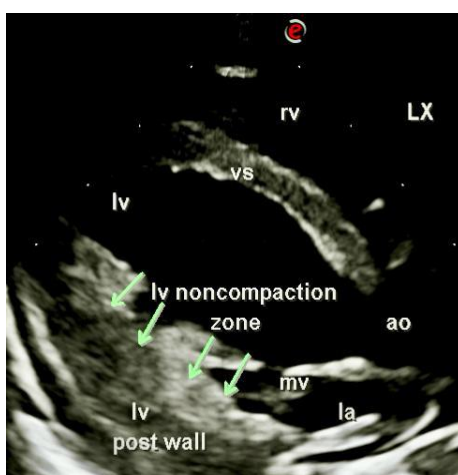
Transthoracic Echocardiography (TTE). In the LX view a salient LV non compacted zone of post wall is demonstrated. lv, left ventricle; la, left atrium; mv, mitral valve; ao, aorta; vs, ventricular septum; rv, right ventricle.
